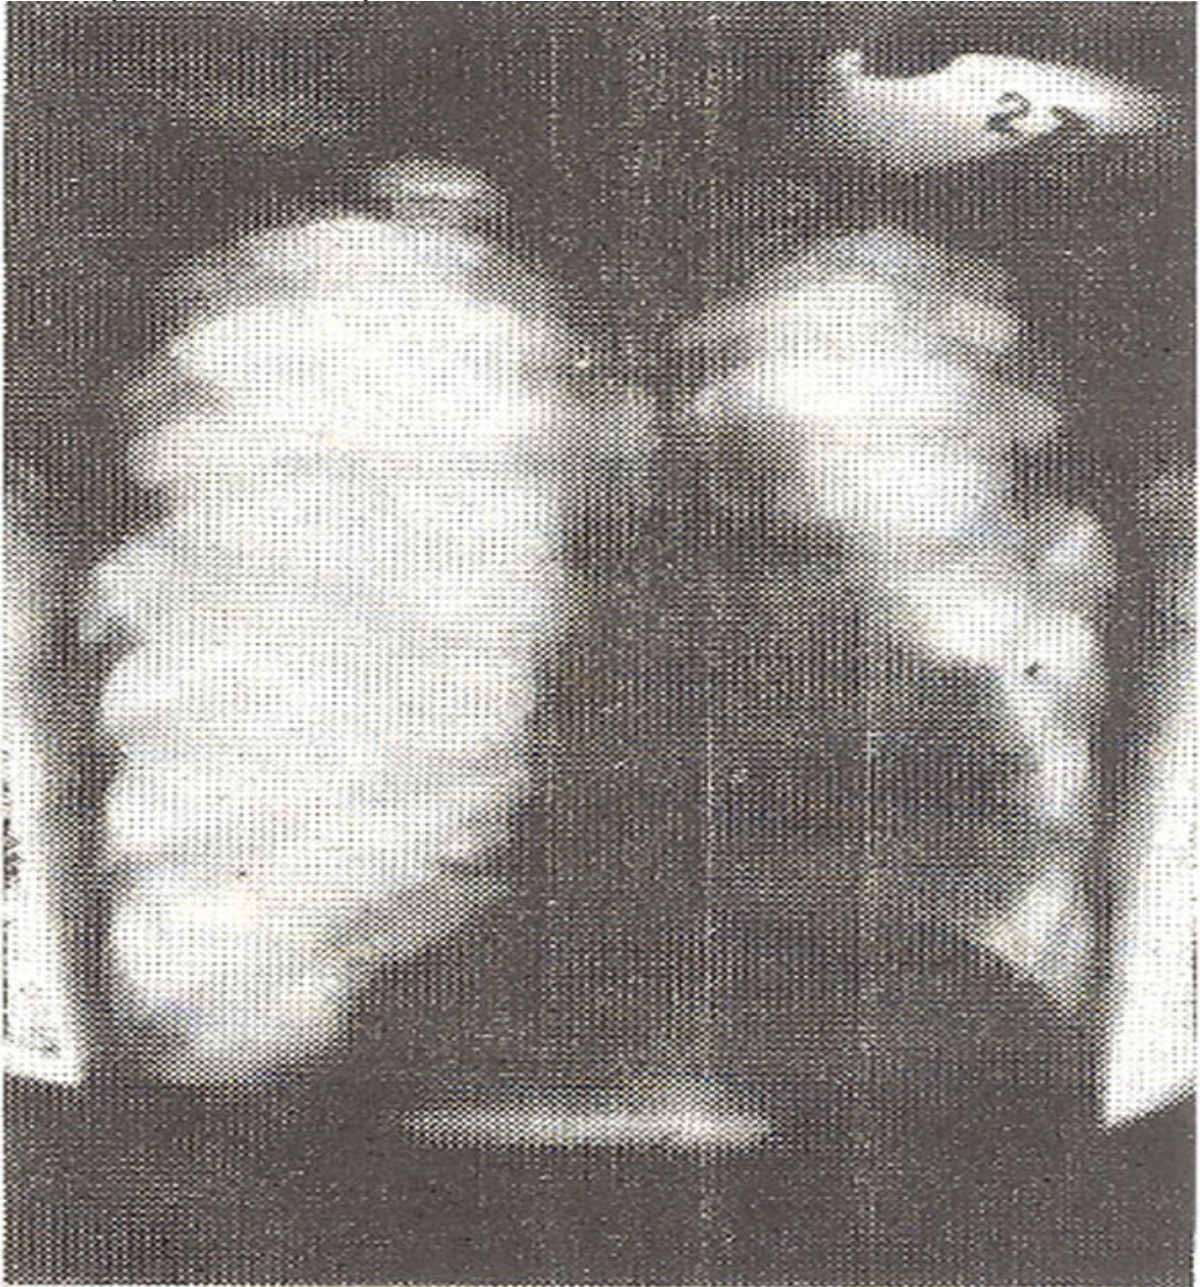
X-ray chest P.A. View. Increased radiolucency of right lung with low dome of diaphragm, trachea and mediastinum shifted towards left side, left dome of diaphragm is raised, linear thickening of pleura over fibrosed and shrunken left lung.
